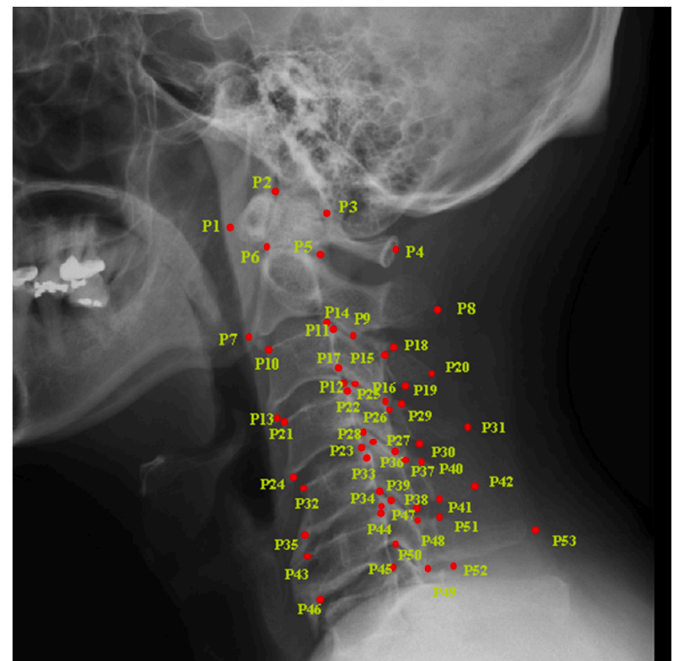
Landmarks on the representative lateral cervical radiograph.
